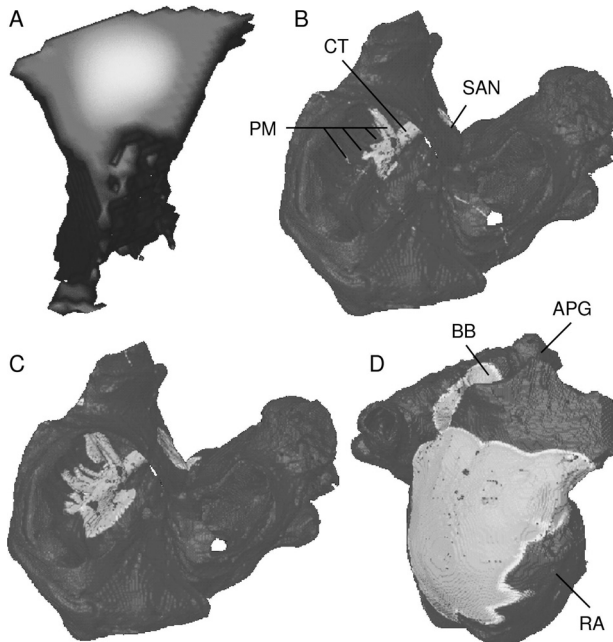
Gray-coded transmembrane voltage during excitation propagation in human atria. (A) SAN visualised only: Activation starts in the centre of the SAN; (B+C) View through valves: Excitation spreads along CT and PM; (D) Lateral view: Right atrium and left via BB gets activated.
